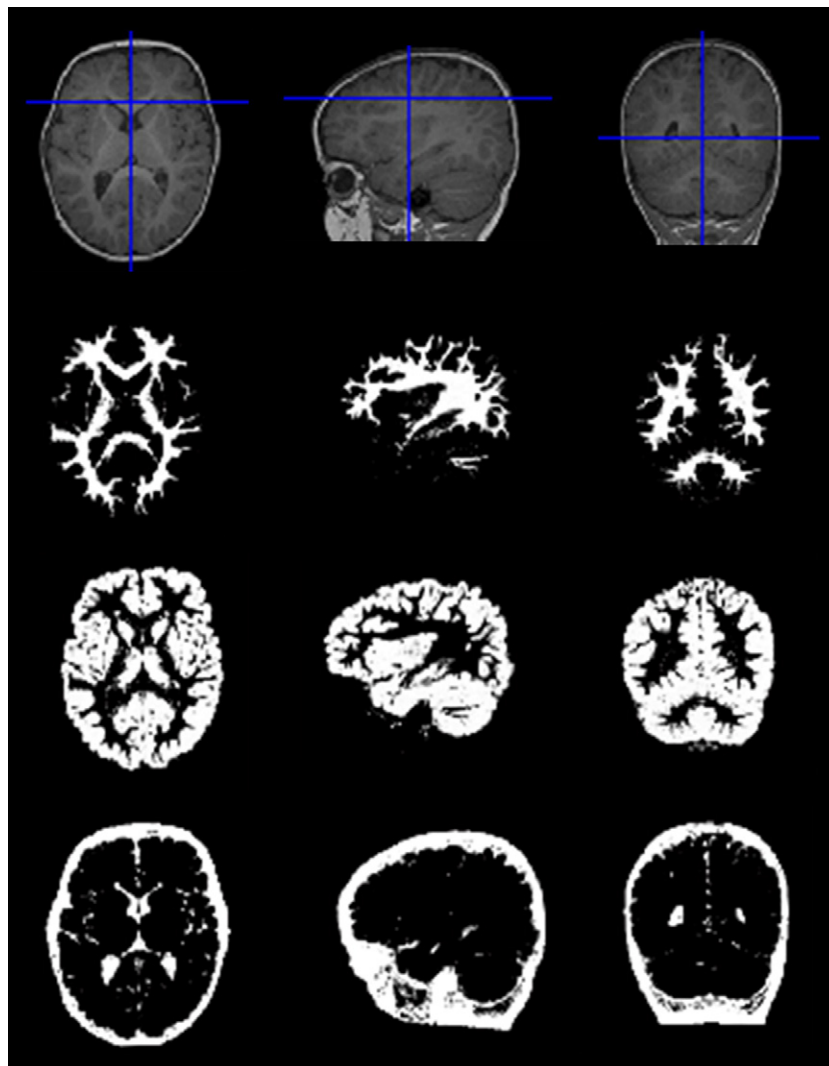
Axial, sagittal and coronal slices from a single subject representing the T1-weighted image (first row), and tissue segmentation at different levels showing white matter (second row), grey matter (third row) and cerebrospinal fluid (fourth row).
